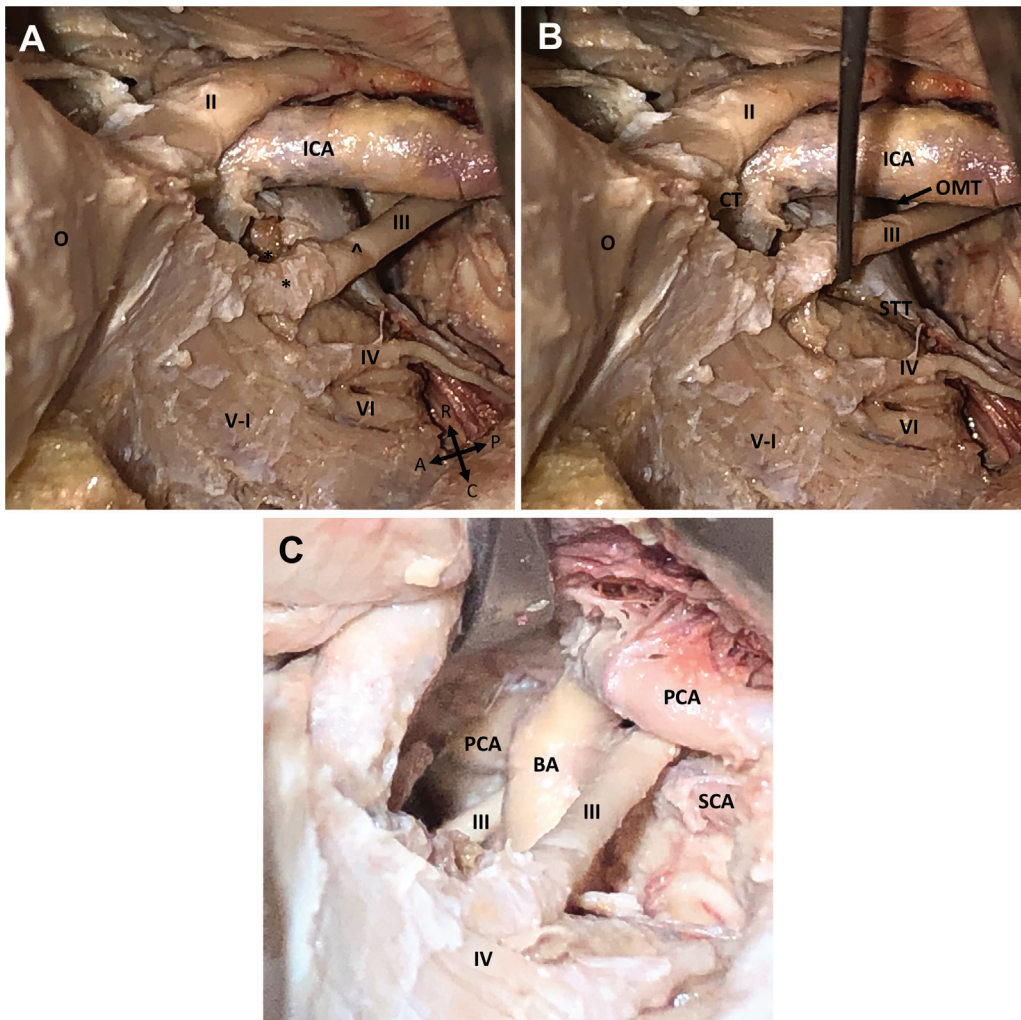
Mobilization of CNIII distal to the oculomotor foramen. (A) When mobilizing CNIII distal to the oculomotor foramen a thin layer of connective tissue (marked with an *) should be left on the nerve due to fusion of the epineurium and the connective tissue of the dura at this level (indentation on CNIII marked with an ^ indicates the level of the porous oculomotorius). (B) This dissection further mobilizes the nerve to increase the operative corridors within the oculomotor, clinoidal, and supratrochlear triangles, allowing increased access to the parasellar, infrachiasmatic, and posterior clinoid regions (C). Left-sided dissection shown. II, optic nerve; III, oculomotor nerve; IV, trochlear nerve; V-I, abducens nerve; V-I, trigeminal nerve—ophthalmic division; A, anterior; BA, basilar artery; C, caudal; CN, cranial nerve; CT, clinoidal triangle; ICA, internal carotid artery; O, orbit; OMT, oculomotor triangle; P, posterior; PCA, posterior cerebral artery; R, rostral; SCA, superior cerebellar artery; STT, supratrochlear triangle.
